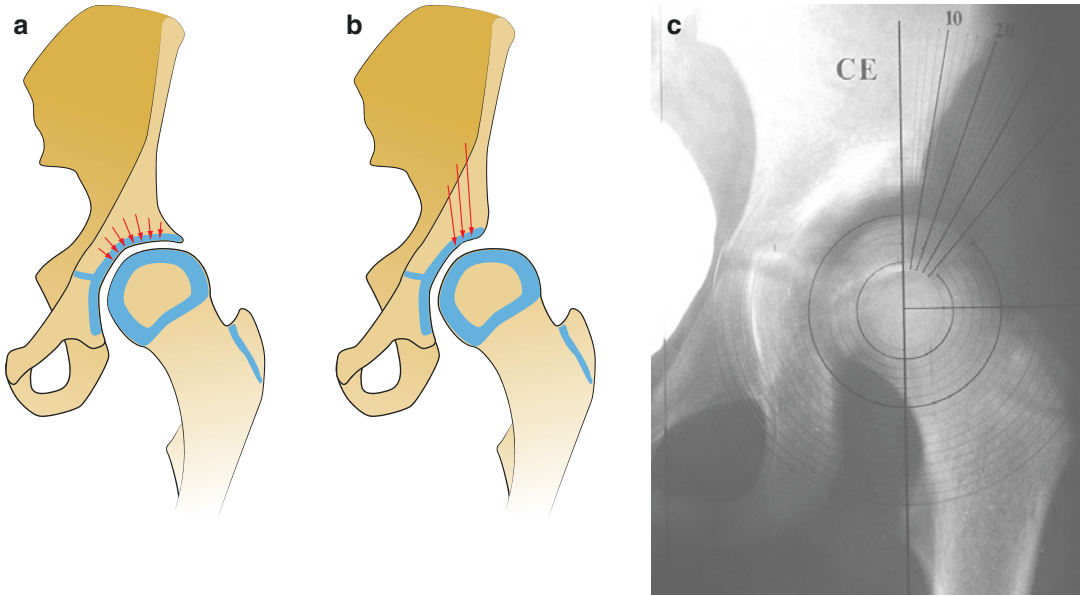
(a) Normal hip. Good distribution of the load on the hip joint. (b) Acetabular dysplasia. Abnormally large load on a part of the hip joint with chances of degenerative changes. (c) In older children and adults, in an anteroposterior X-ray of the hip the relation between the acetabulum and the femoral head is displayed by means of the CE angle of Wiberg. C stands for “center” and E for “lateral Edge of the acetabular roof”. The CE angle is formed by a line
